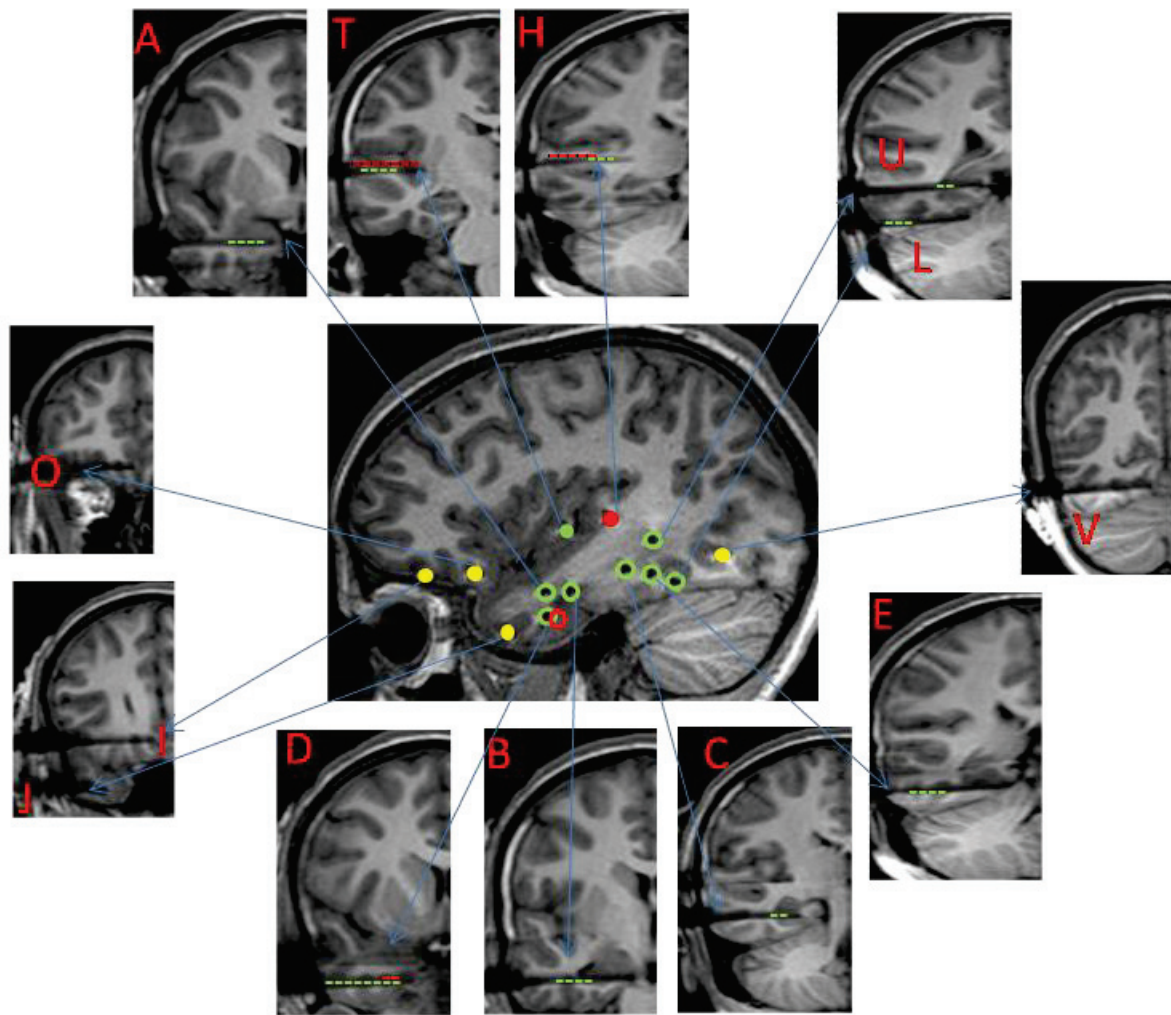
1: Patient 1 MRI with electrodes in place (Right hemisphere). Central sagittal image: each insular electrode is represented by a unique colored solid circle; non-insular electrodes are represented by empty circles with the color of each of the insular electrode they are responding to. Yellow solid circles are for non responding electrodes. Peripheral coronal images: a cross-section of each electrode with its name and its responding contacts (responses are indicated by color coded dotted lines, representing the color of the corresponding stimulated insular electrode).
